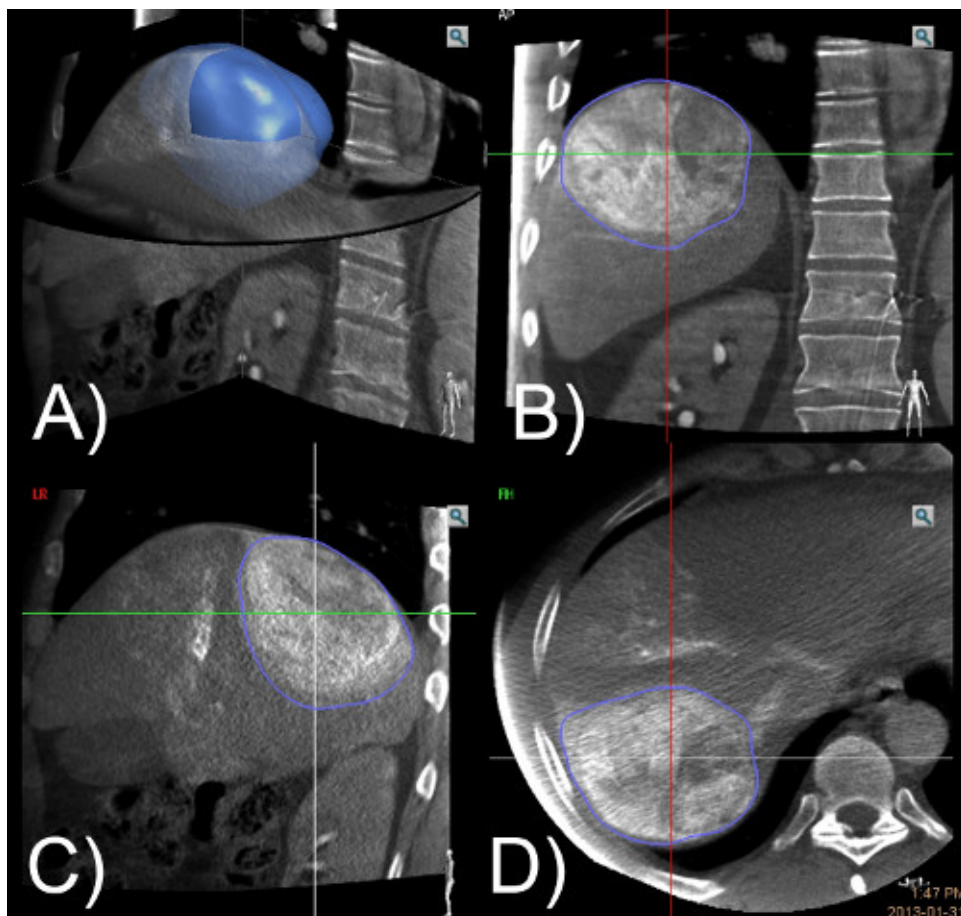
The delayed venous phase CBCT scans is shown on the workstation in three planes and allows for more precise 3D tumor segmentation (A). The tumor volume is represented in blue colored circle in three planes. The segmentation can be done in any of the three axes: coronal (B), sagittal (C), and axial (D).
